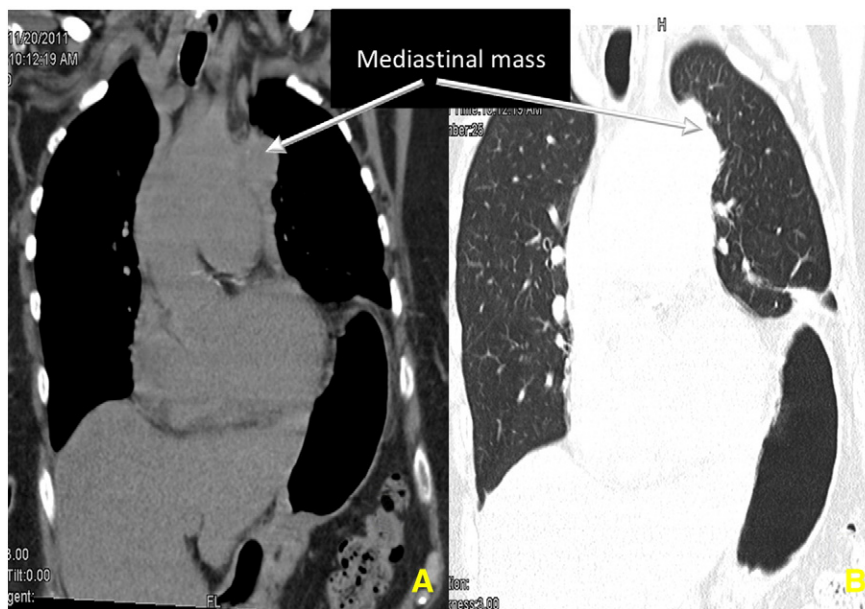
Coronal computed tomographic (CT) scan showing extension of the pericardial effusion, left hiatus hernia, and mediastinal mass. (A) Non-enhanced. (B) Contrast enhanced.
